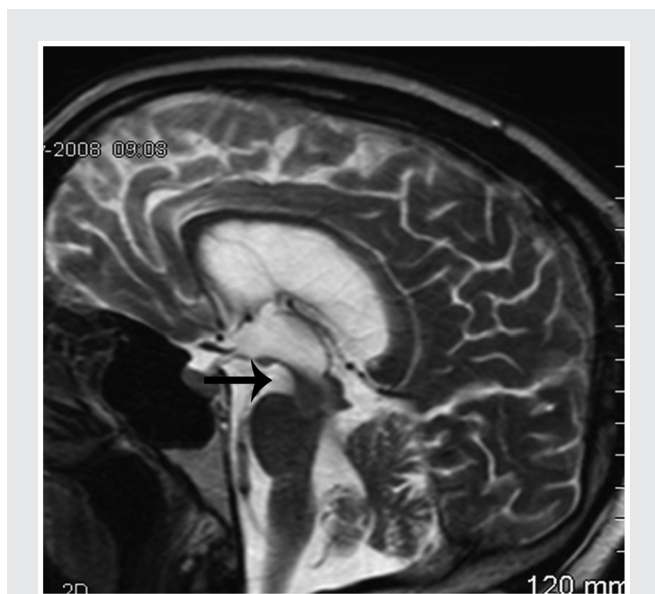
Sagittal T2-weighted brain MRI of a patient with progressive supranuclear palsy-Richardson syndrome demonstrating substantial atrophy of the midbrain, yielding the “hummingbird sign” (arrow). Associated frontal-predominant atrophy, as demonstrated by thinning of the anterior portion of the corpus callosum and ex vacuo hydrocephalus is also present.
